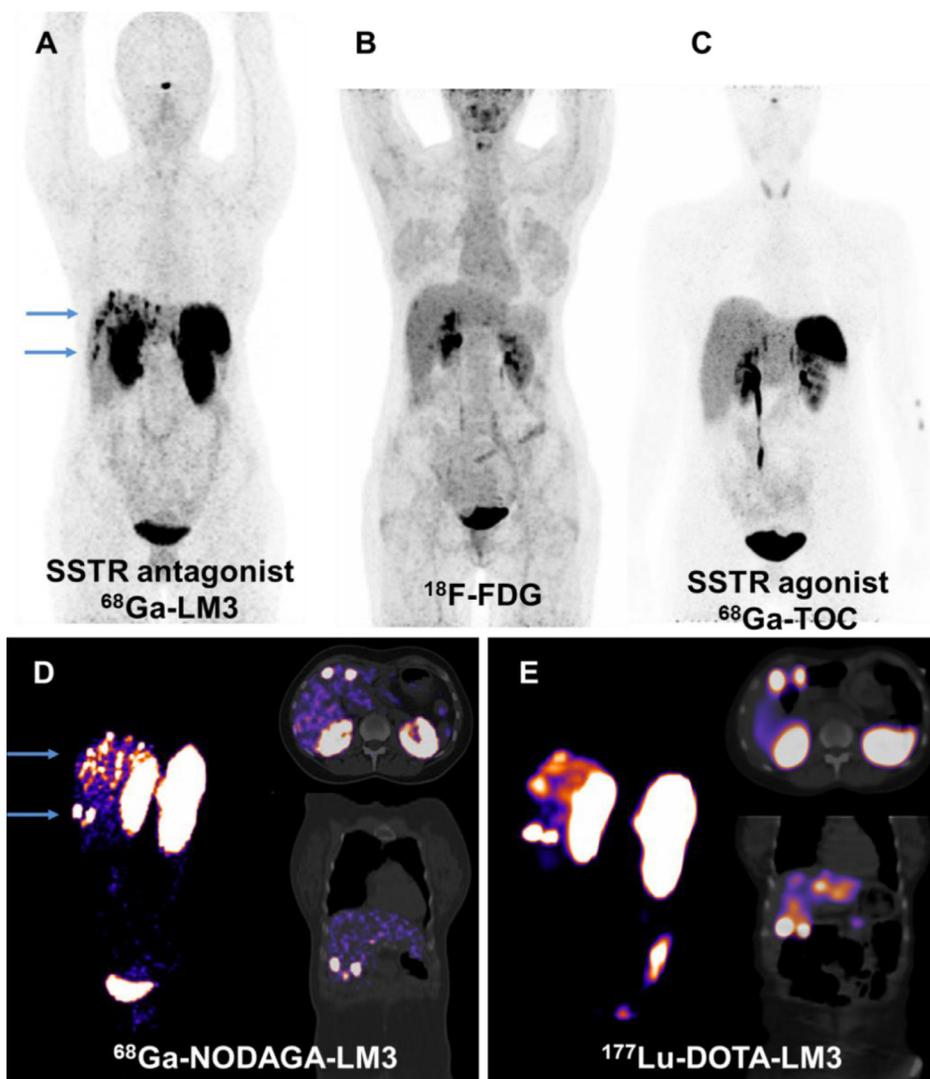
Dissemminated liver metastasis detection by SSTR antagonist: theranostics approach using Ga-68/Lu-177 LM3 for imaging and intra-arterial PRRT. A 29-year-old woman was diagnosed in 2017 with a well-differentiated nonfunctional, pancreatic neuroendocrine neoplasm with hepatic metastases. The Ki-67 proliferation index (biopsy) was 15% for the inoperable primary tumor and 20% for hepatic metastases. Initial tumor classification pT2 pN0 (0/16) cM1 (HEP) G2 L0 V0 Pn0 R0, stage IV (World Health Organization 2017). The biomarkers chromogranin A, synaptophysin, and cytokeratin MNF116 were elevated. Multiple (at least 25) small, bilobar-distributed somatostatin receptor-positive liver metastases were detected by on PET/CT using antagonist Ga-68 NODAGA-LM3 (A), as compared to somatostatin receptor agonist (B) Ga-68 DOTATOC. (C) ^{18}F -FDG-PET/CT. (D) Somatostatin receptor expression in multiple liver metastases on Ga-68 NODAGA-LM3 PET/CT. (E) Post-therapy Lu-177 DOTA-LM3 (intra-arterial, 6.9 GBq) SPECT/CT.
